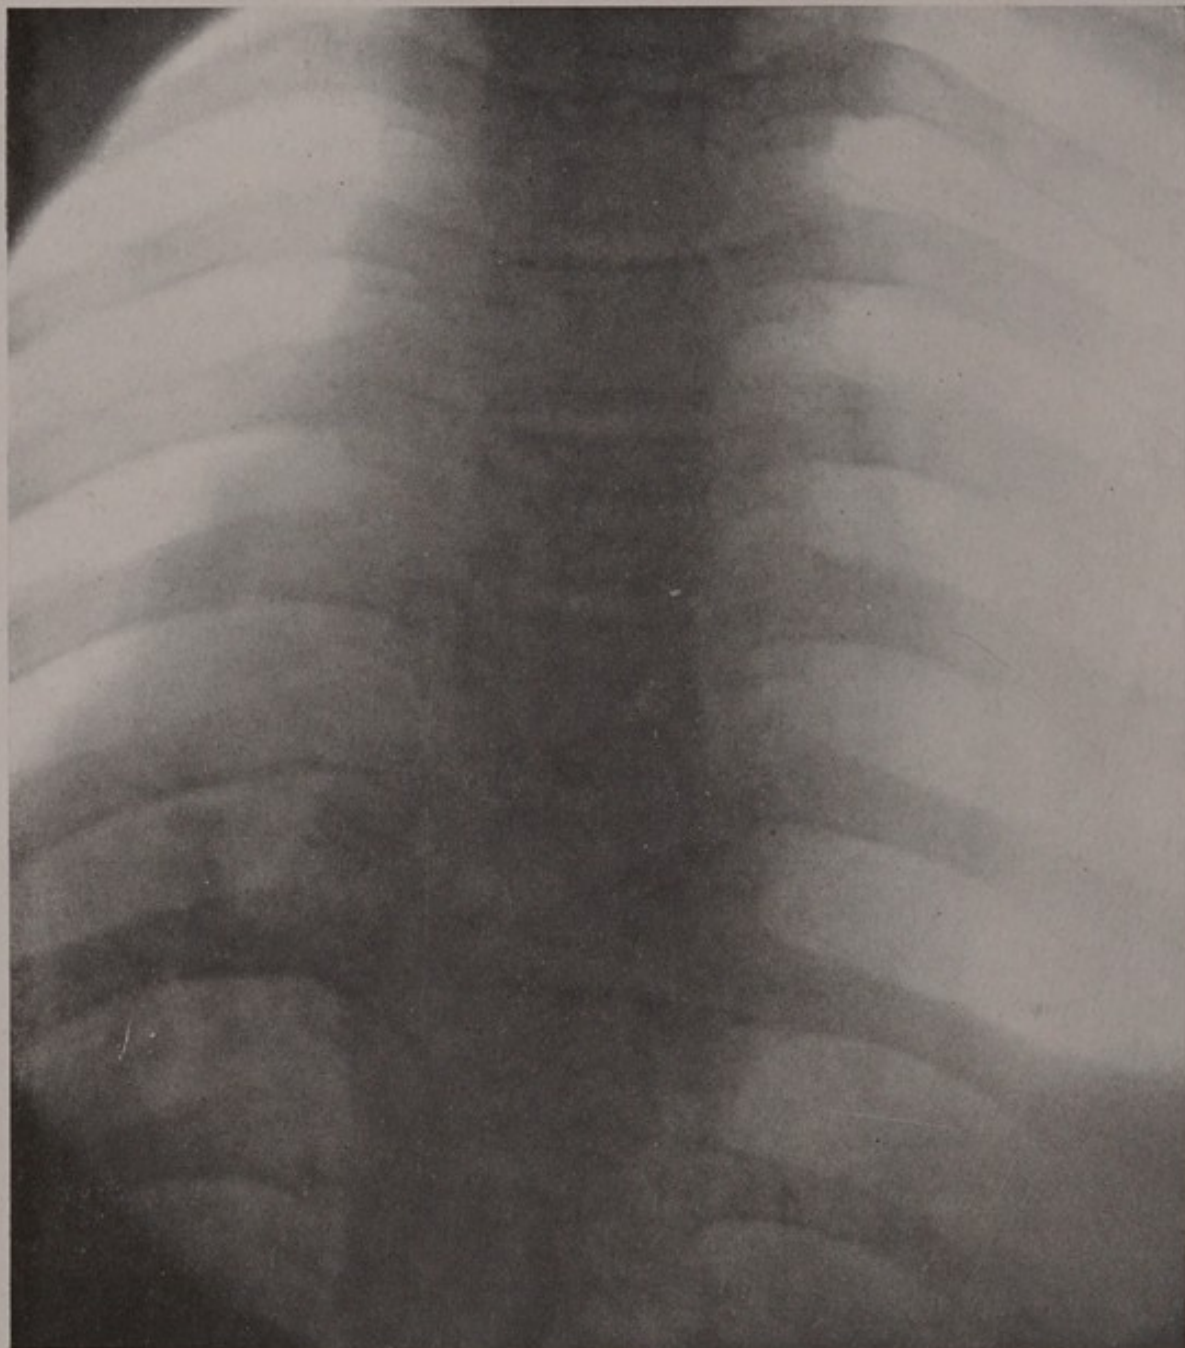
X-ray of fracture of the eighth and ninth dorsal vertebræ eight years after the injury.
